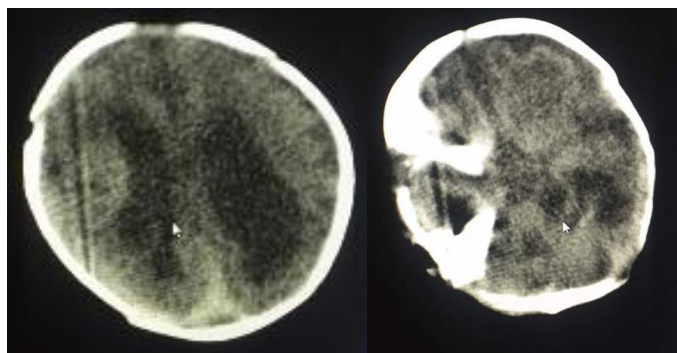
Brain CT scan on the second day (grade IV intraventricular hemorrhage and severe atrophy of the brain).
